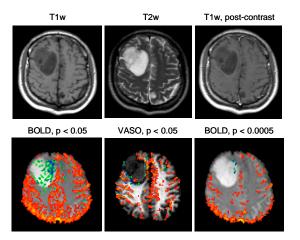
Morphological and functional MR images of a patient. Increases in signal (BOLD) or CBV (VASO) were shown in yellow to red color, while decreases in green to blue.
